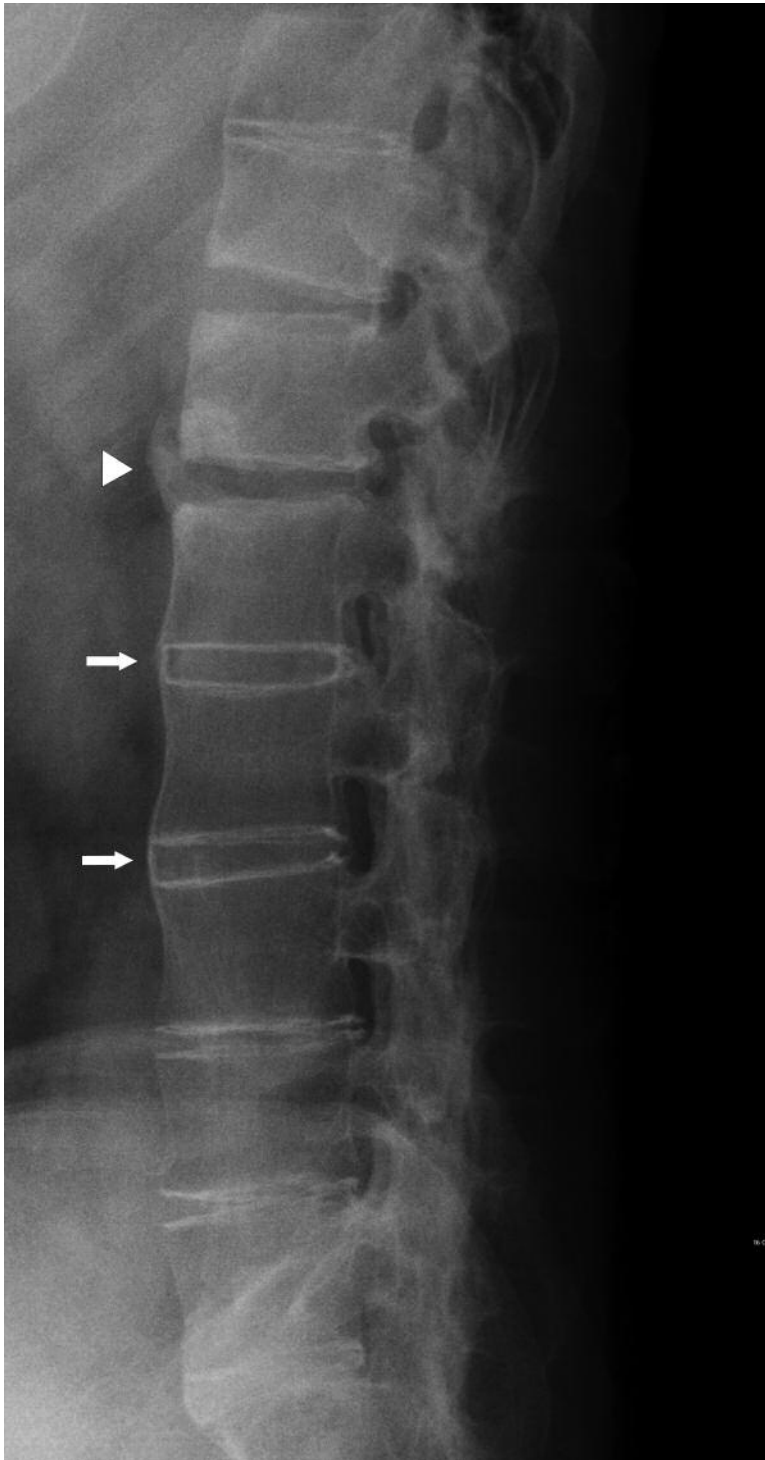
Lateral lumbar radiograph from one of our patients shows total bony bridging from the lower border of first lumbar vertebra to the upper border of third lumbar vertebra (arrows) and bony sclerosis without fusion between the 12th thoracic vertebra and first lumbar vertebra (arrowhead).
